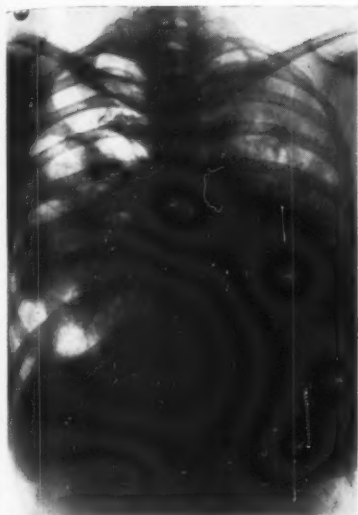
POSTERO-ANTERIOR RADIOGRAPH (18.10.49) SHOWING EXTENSIVE BILATERAL SHADOWING WHICH PROVED TO BE ADENOMATOSIS ON THE RIGHT SIDE AND BRONCHIECTASIS ON THE LEFT.
